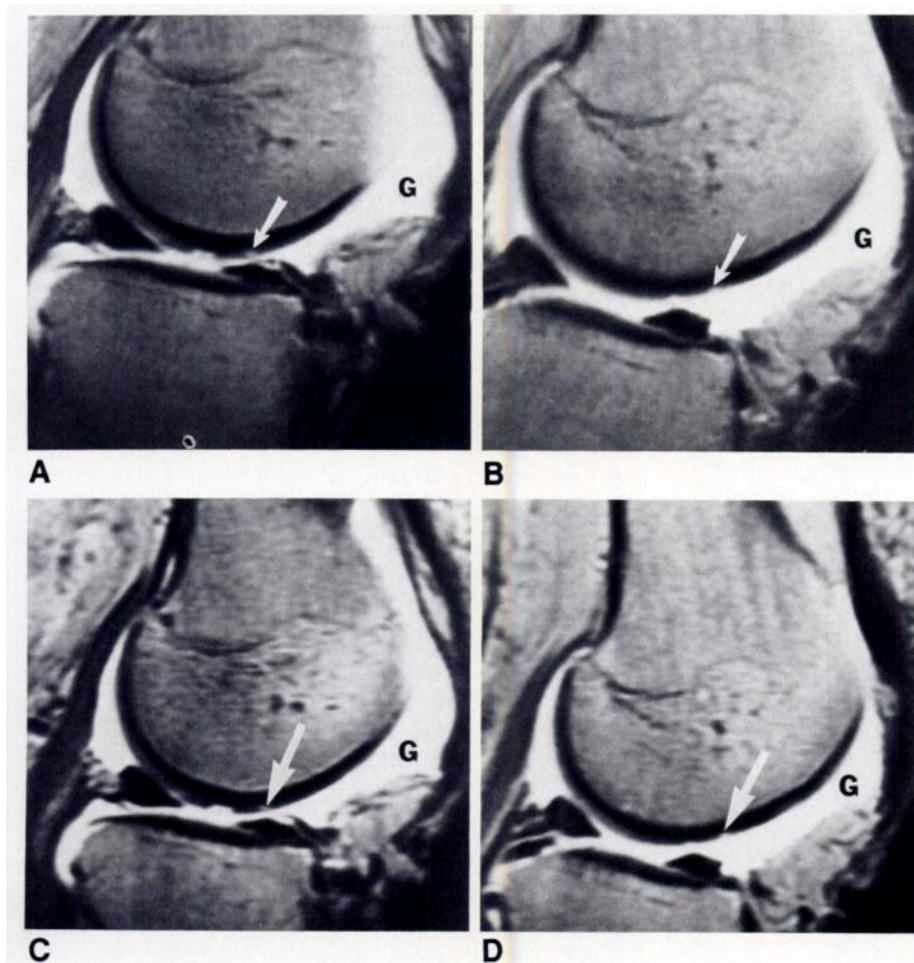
MR images (TR = 600 msec/TE = 25 msec) of cartilage defects after intraarticular administration of $500 \mu\text{M}$ Gd-DTPA (G).
